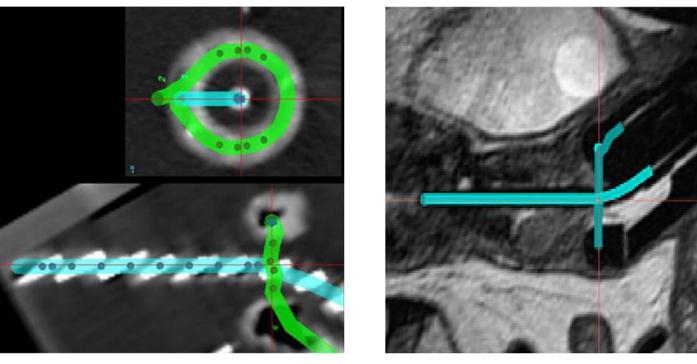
Image-guided brachytherapy in cervical cancer is increasingly replacing X-ray based dose planning. In image-guided brachytherapy the geometry of the applicator is extracted from the patient 3D images and introduced into the treatment planning system; a process referred to as applicator reconstruction. Due to the steep brachytherapy dose gradients, reconstruction errors can lead to major dose deviations in target and organs at risk. Appropriate applicator commissioning and reconstruction methods must be implemented in order to minimise uncertainties and to avoid accidental errors.
